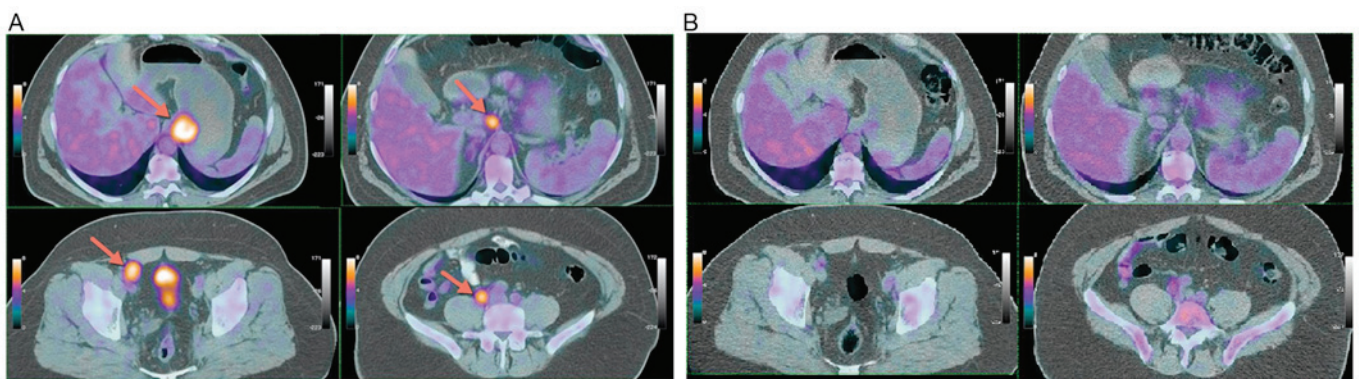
(A) Case 1: PET/CT at diagnosis revealing the primary tumor, one hypermetabolic paraortic and pelvic (right ileac and inguinal) lymph nodes. (B) Case 1: PET/CT scan following two chemotherapy cycles. Corresponding slices to the findings presented in (A). PET/CT, positron emission tomography/computed tomography.
